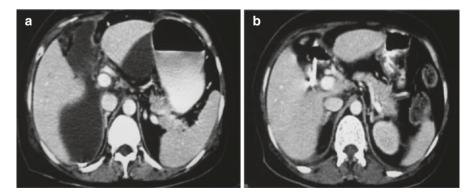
Utility of a contrast-enhanced computed tomography/CT scan in the management of intra-abdominal collections. (a) Post-cholecystectomy biloma. (b) Post-percutaneous drainage (PCD) axial section in the same patient demonstrating a complete resolution in the collection
